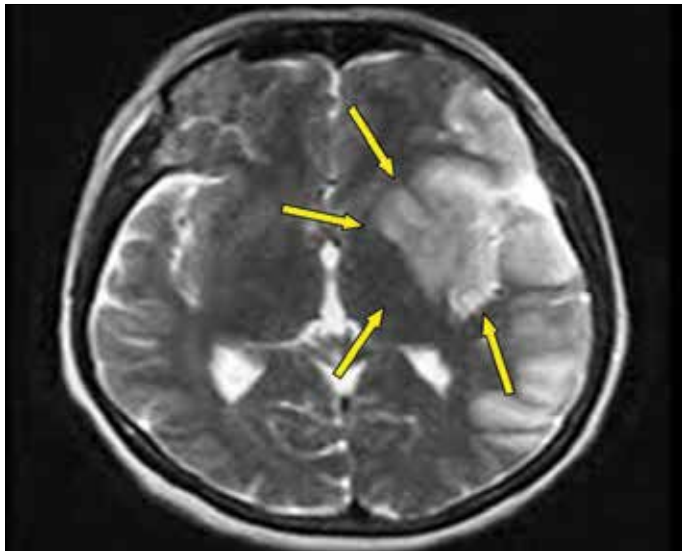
Brain MRI images of acute cerebral infarctions in the left middle cerebral artery territory (arrows)
